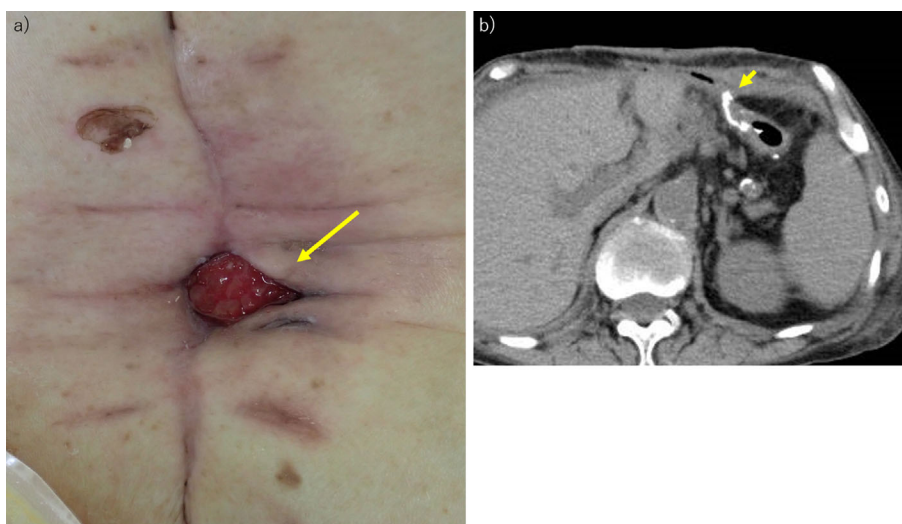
a) Cutaneous opening of the jejunocutaneous fistula (yellow arrow). b) Computed tomography image of the jejunocutaneous fistula (yellow arrow).
